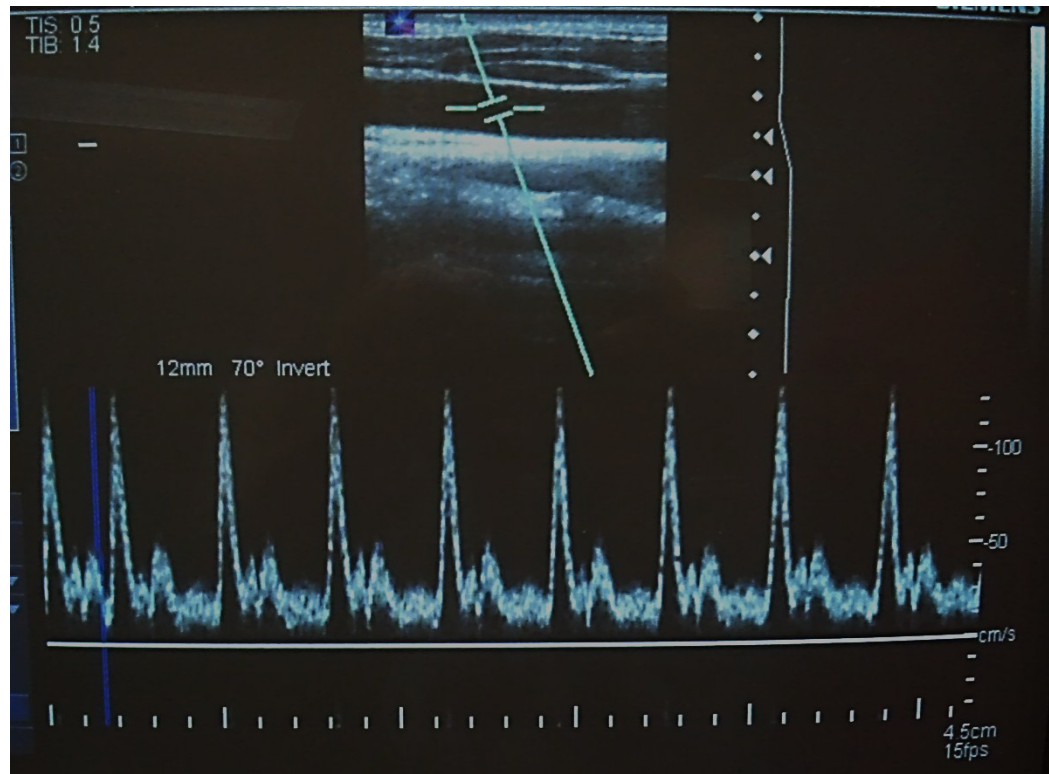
A screen shot of spectral Doppler showing both B-mode image and spectrogram of the carotid artery. The Doppler signal is collected from the gate along the beam direction.
